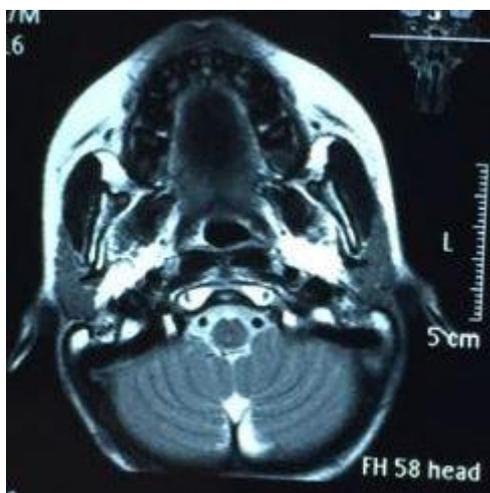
CT image of the patient: showing post radiotherapy changes at tongue
